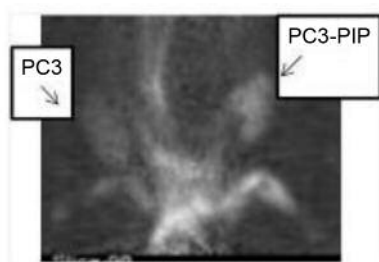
MicroPET imaging data after intravenous injection of ^{18}F -FDG demonstrated uptake in PSMA positive and negative tumors (PC3-PIP and PC3 cells).
